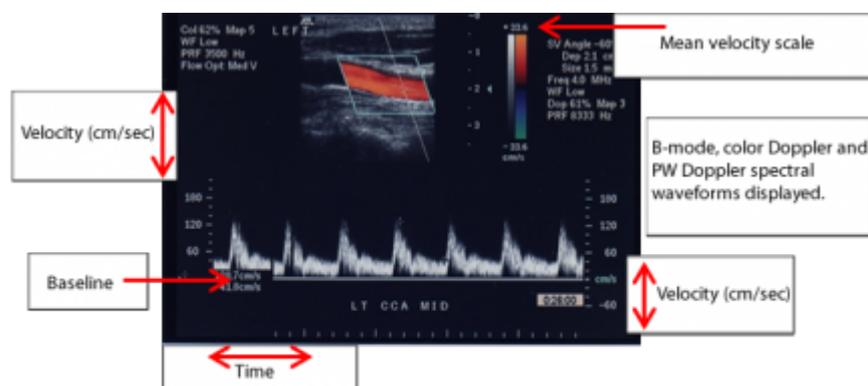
Identification of some key information that is included on a duplex image with color Doppler
